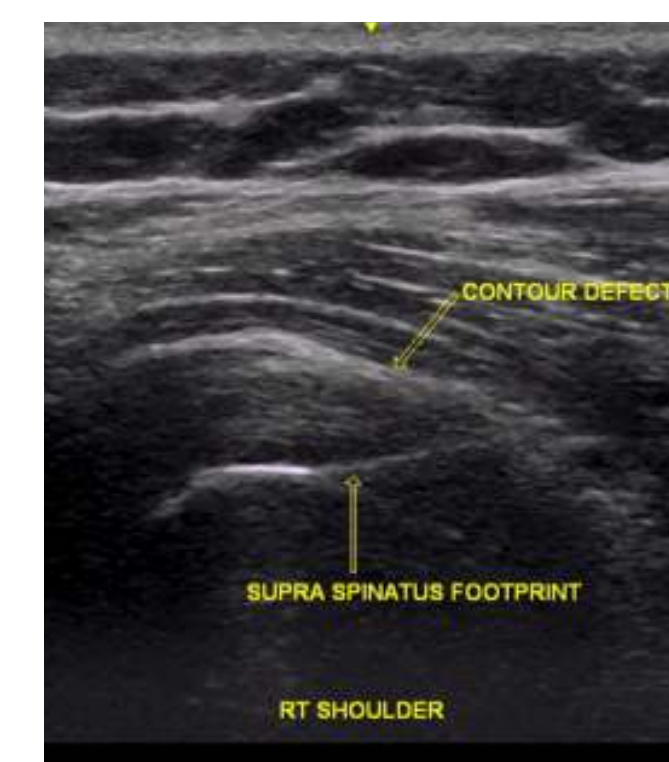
Pre-treatment ultrasound image of the supraspinatus tendon reveals a hypoechoic, heterogeneous echotexture with thinning of the supraspinatus tendon showing a contour defect (arrow), consistent with a tear.
